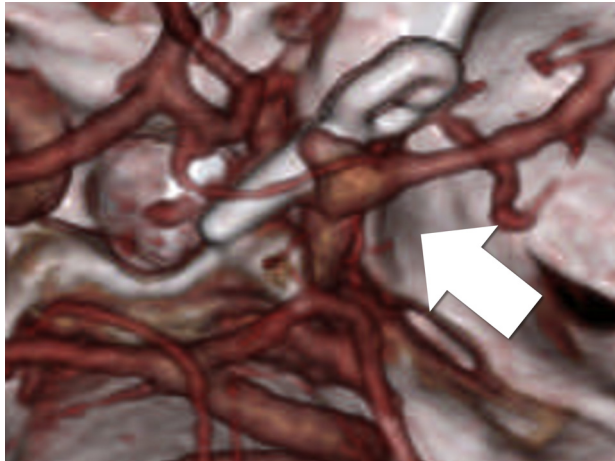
Three-dimensional computed tomography angiography 2 weeks after the first operation shows the growing tendency of the remnant of the aneurysm (*white arrow*).
